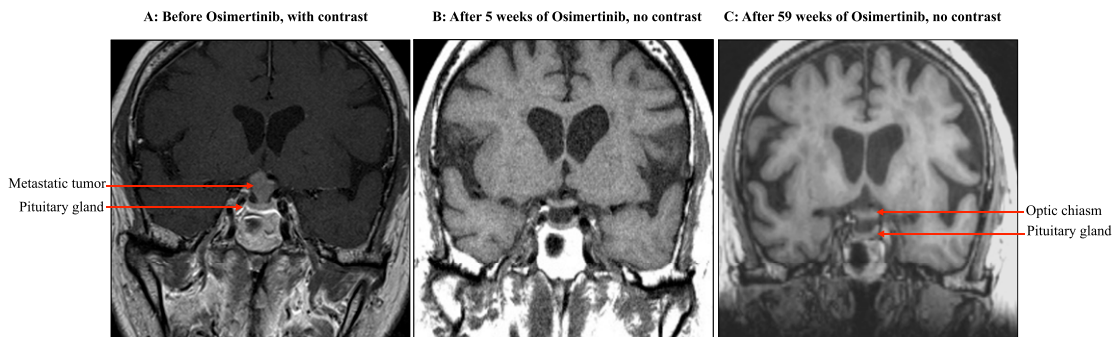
T1-weighted MRI coronal views of the sella. (A) Before osimertinib, a T1-weighted MRI coronal view with contrast material showed a $7 \times 11 \times 21$ -mm (anterior-posterior \times transverse \times superior-inferior) intrinsically T1-isointense, T2-hyperintense, enhancing lesion in the sella and suprasellar region involving the infundibulum, posterior pituitary gland, and hypothalamus. Sagittal view (data not shown) revealed that the normal T1 hyperintensity signal in the posterior pituitary gland disappeared. This lesion abutted the posterior aspect of the optic chiasm and displaced the postchiasmatic optic tracts superiorly and laterally. The cavernous sinuses appeared unremarkable. (B) T1-weighted MRI coronal view without contrast material (because of new renal dysfunction) 5 wk after initiation of osimertinib is shown. Note the resolution of the metastatic lesion and restoration of normal sellar structure. (C) T1-weighted MRI coronal view without contrast material 59 wk after initiation of osimertinib is shown. Note the persistent resolution of the metastatic lesion.
